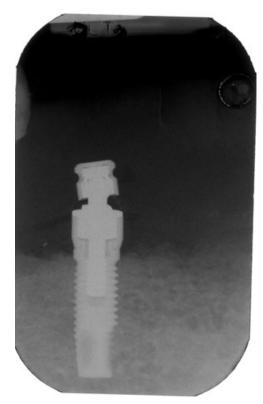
A periapical radiograph of an implant immediately after placement and prosthetic connection. The implant threads are clearly seen both mesially and distally.
